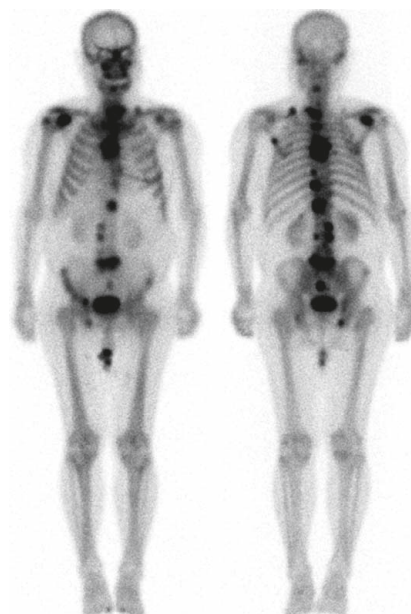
Multiple bony metastases are shown in this Tc-99m MDP whole body bone scintigraphy scan of a patient with prostate cancer.
